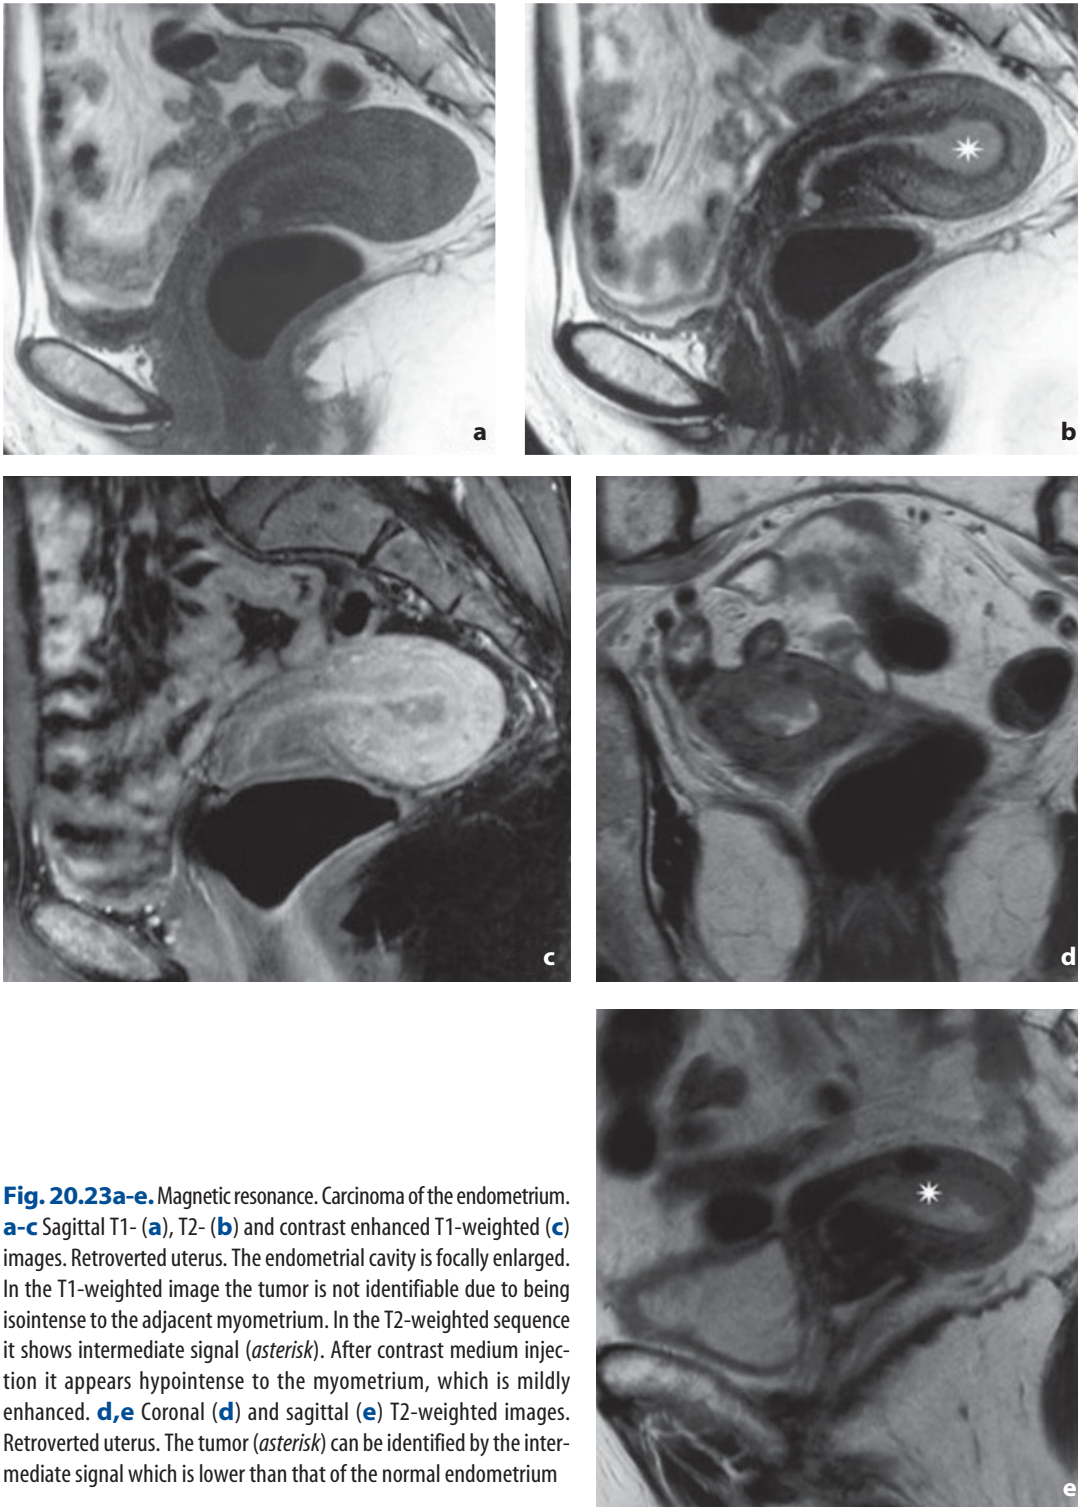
Magnetic resonance. Carcinoma of the endometrium. a-c Sagittal T1- (a), T2- (b) and contrast enhanced T1-weighted (c) images. Retroverted uterus. The endometrial cavity is focally enlarged. In the T1-weighted image the tumor is not identifiable due to being isointense to the adjacent myometrium. In the T2-weighted sequence it shows intermediate signal (*asterisk*). After contrast medium injection it appears hypointense to the myometrium, which is mildly enhanced. d,e Coronal (d) and sagittal (e) T2-weighted images. Retroverted uterus. The tumor (*asterisk*) can be identified by the intermediate signal which is lower than that of the normal endometrium
